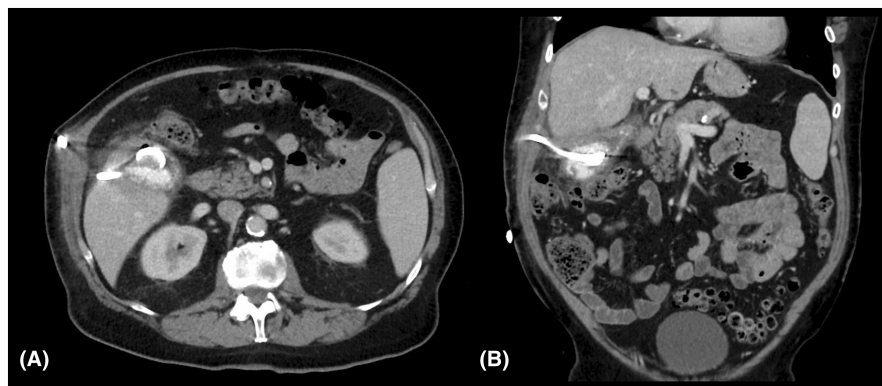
Preoperative CT imaging demonstrating the presence of several small, calcified stones with the gallbladder lumen and evidence of ongoing inflammation despite cholecystostomy tube placement and optimization. (A) Axial. (B) Coronal.
